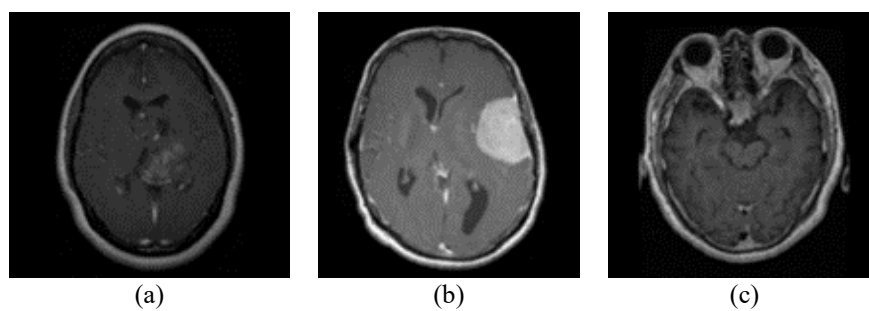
Input MRI images of (a) glioma, meningioma, and (c) pituitary
